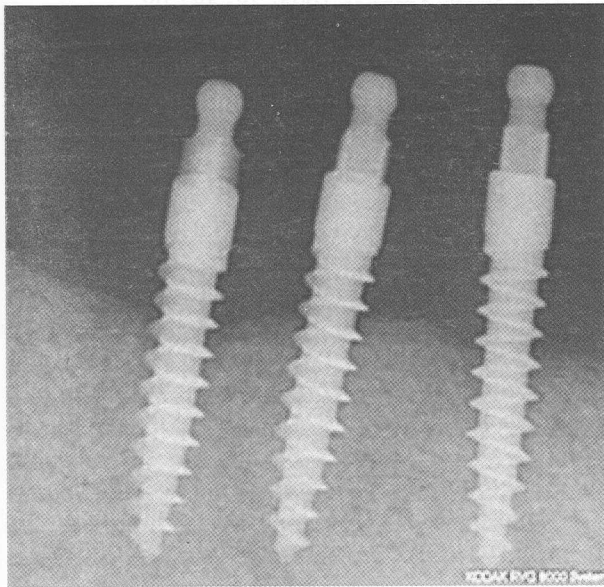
Periapical radiographs showing mini implants at lower right quadrant 20 months post-loading. There is an increase in peri-implant marginal bone loss of approximately one to two threads from the time of insertion.
